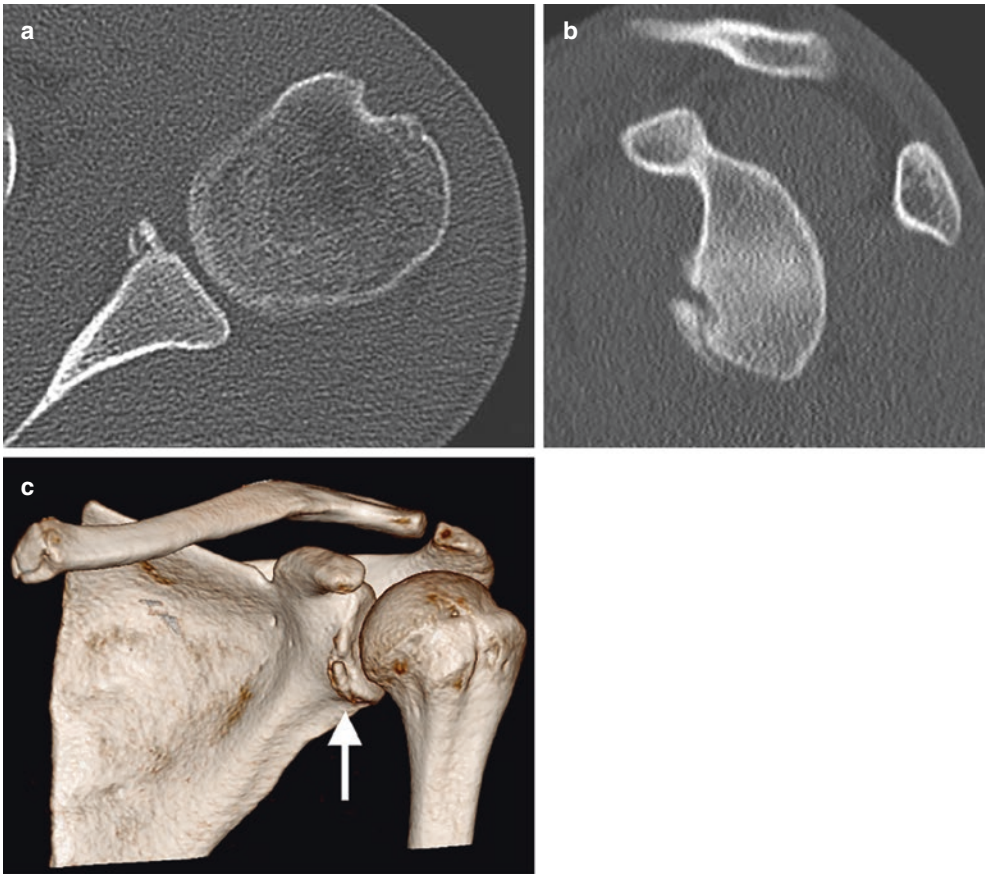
Bony Bankart on CT scan. (a) Axial cut; (b) sagittal cut; (c) 3D reconstruction
